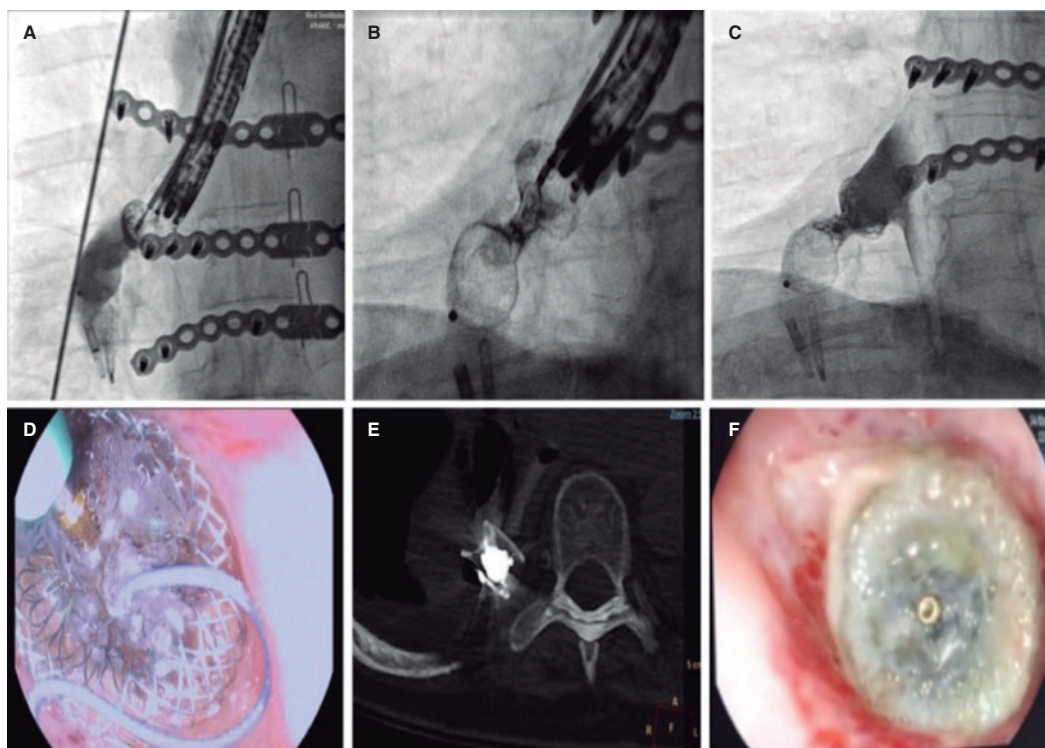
A: fluoroscopic projection showing the release of a 14 mm Amplatzer muscular VSD occluder. B: administration of the Onyx Liquid inside the neck of the Amplatzer device using a microcatheter (note the device neck turned radiolucent). C: contrast injection into the esophagus confirming the immediate sealing of the device. D: endoscopic view of the microcatheter during the injection of the embolic sealing liquid. E: computed tomography scan showing the device with an embolic sealing agent inside. F: endoscopic image of the device after 1-month showing partial endothelialization.
